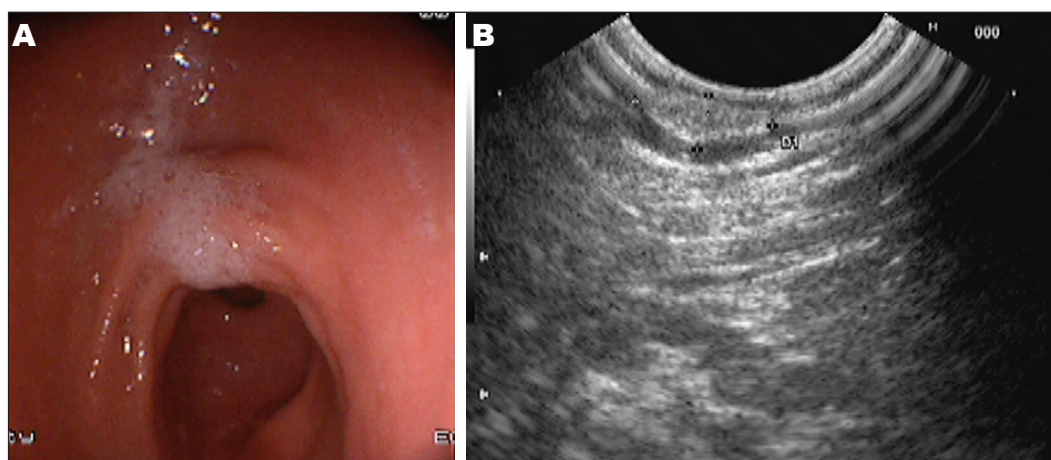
A: Endoscopic view showing a smooth protrusion in the gastric antrum; B: Endoscopic ultrasound showing a heterogeneous hypoechoic mass with poorly-defined borderline, origination from the third layer. Pathology after endoscopic resection confirmed that the lesion was an aberrant pancreas.
